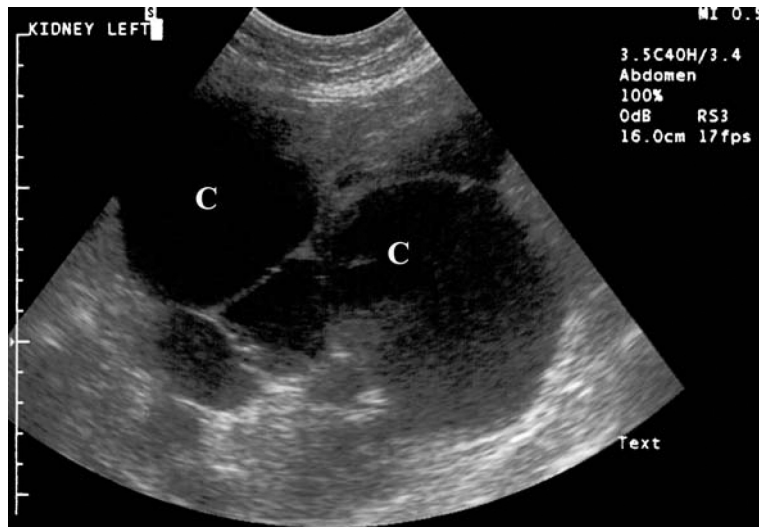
Ultrasound of a polycystic kidney showing how the normal tissue is replaced by multiple fluid-filled cysts (C).
